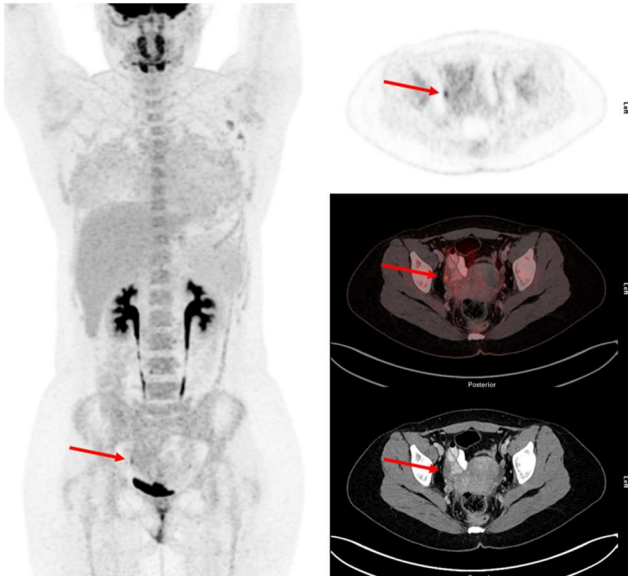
FDG PET/CT scan showing slightly increased FDG uptake corresponding to a structurally normal right ovary on CT (arrows). The uterus and left ovary were normal on FDG PET/CT. No suspicious findings in lymph nodes or the peritoneal cavity. The FDG uptake corresponding to the right ovary was interpreted as physiological uptake which was supported by a magnetic resonance scan without any significant pathological findings. *Abbreviations:* FDG PET/CT; 18F-fluorodeoxyglucose positron emission tomography/computed tomography.
